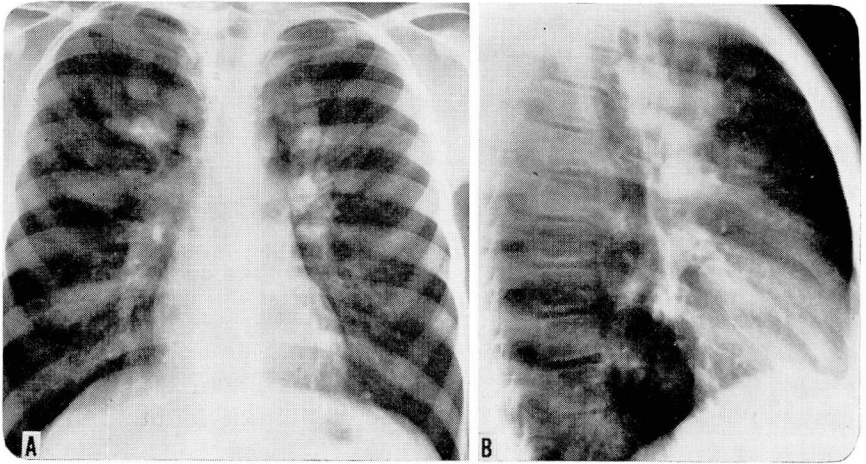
Initial chest roentgenograms showing multiple oval and tubular densities radiating from the hilar region bilaterally into the upper and midlung fields.
